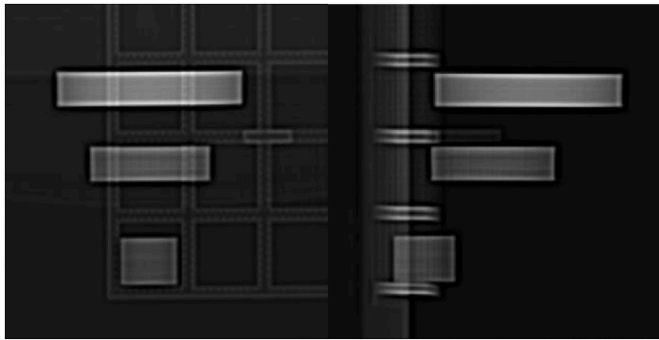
CT image of discs of different XCT filament diameters and infill percentages.
